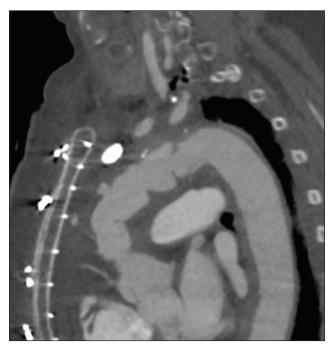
Sagittal CT scan of the thoracic aorta after total arch repair before TEVAR.
